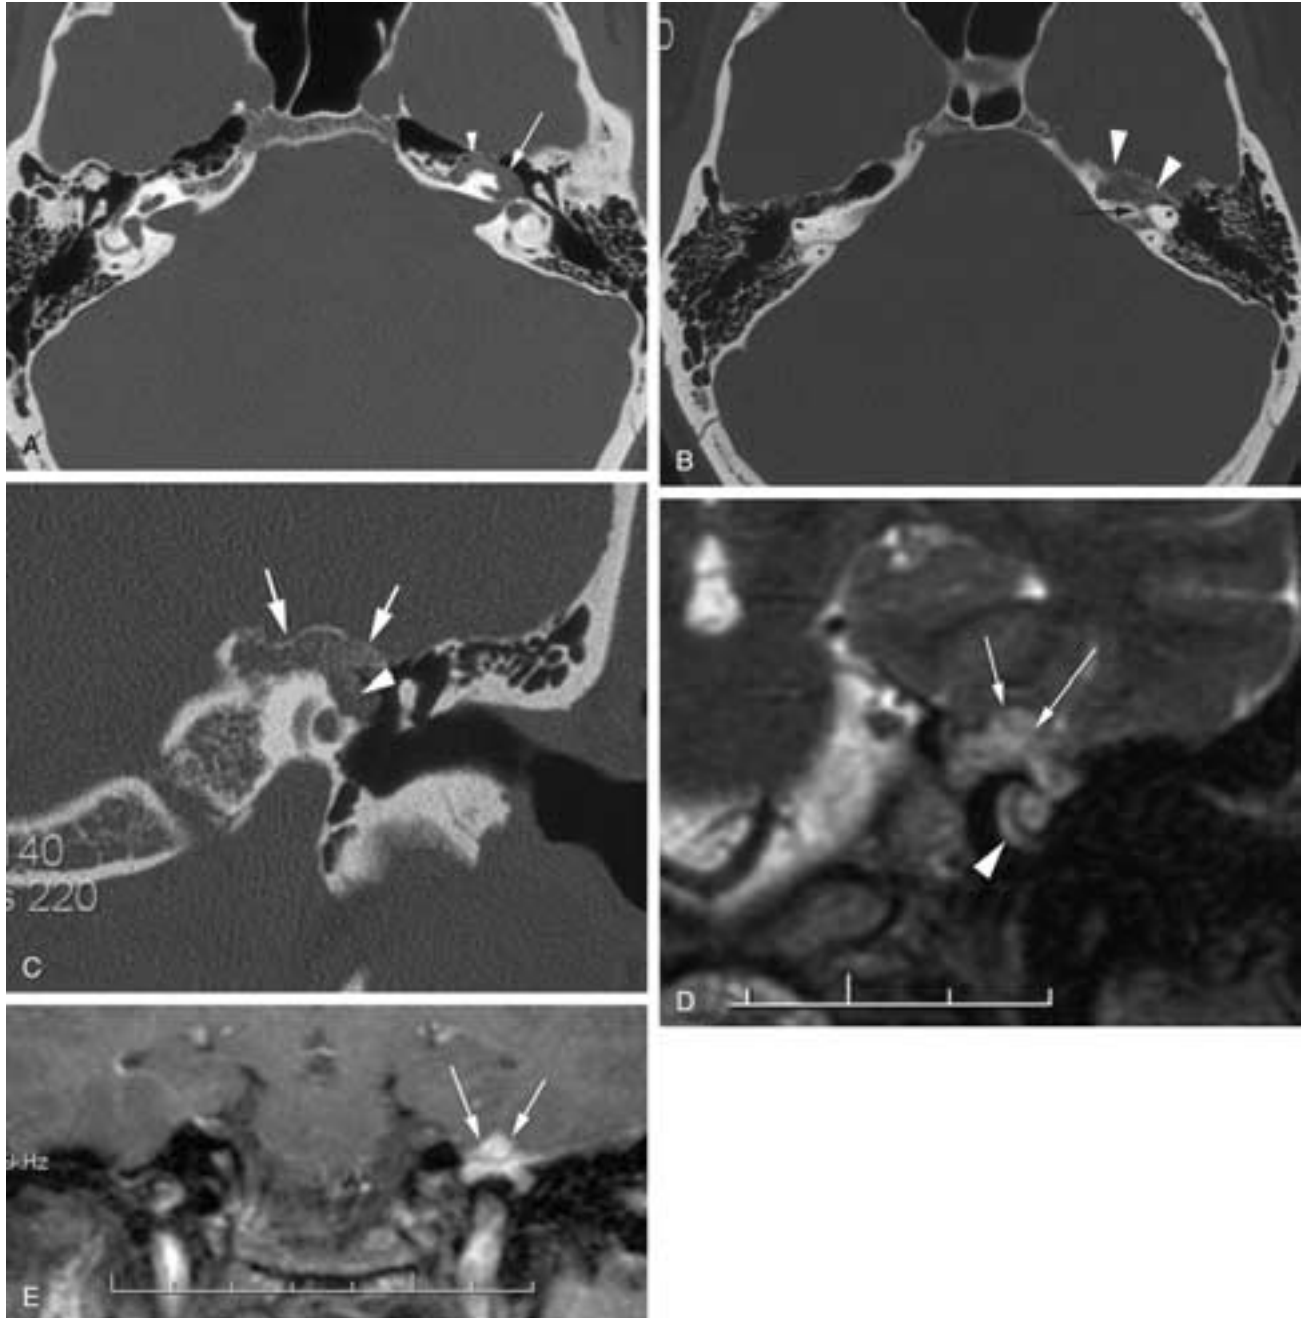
Intratemporal vascular tumor in the region of the geniculate ganglion. A, Axial CT image through the geniculate ganglion shows expansion of the facial nerve (*arrow*). There is irregular bone extending medially toward the petrous apex (*arrowhead*). B, Slightly superior to A, there is demineralization in the region of the labyrinthine segment of the canal (*black arrow*). Note that the lesion (*arrowheads*) contains small spicules of bone. C, Coronal CT image shows the demineralized bone (*arrows*). The abnormality extends inferiorly to enlarge the FNC (*arrowhead*) and involve the facial nerve. D, Coronal T2-weighted MR image shows the relatively high signal (*arrows*) of the vascular lesion. The fluid within the cochlea (*arrowhead*) is noted for comparison and orientation. E, Coronal postcontrast gadolinium T1-weighted image shows the enhancement (*arrows*) of the lesion. (Courtesy of Dr. H.D. Curtin.)
